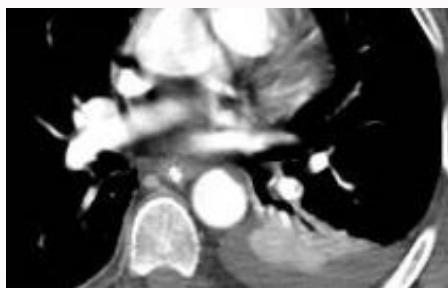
CT angiography showing lower lobar arterial pulmonary emboli.
